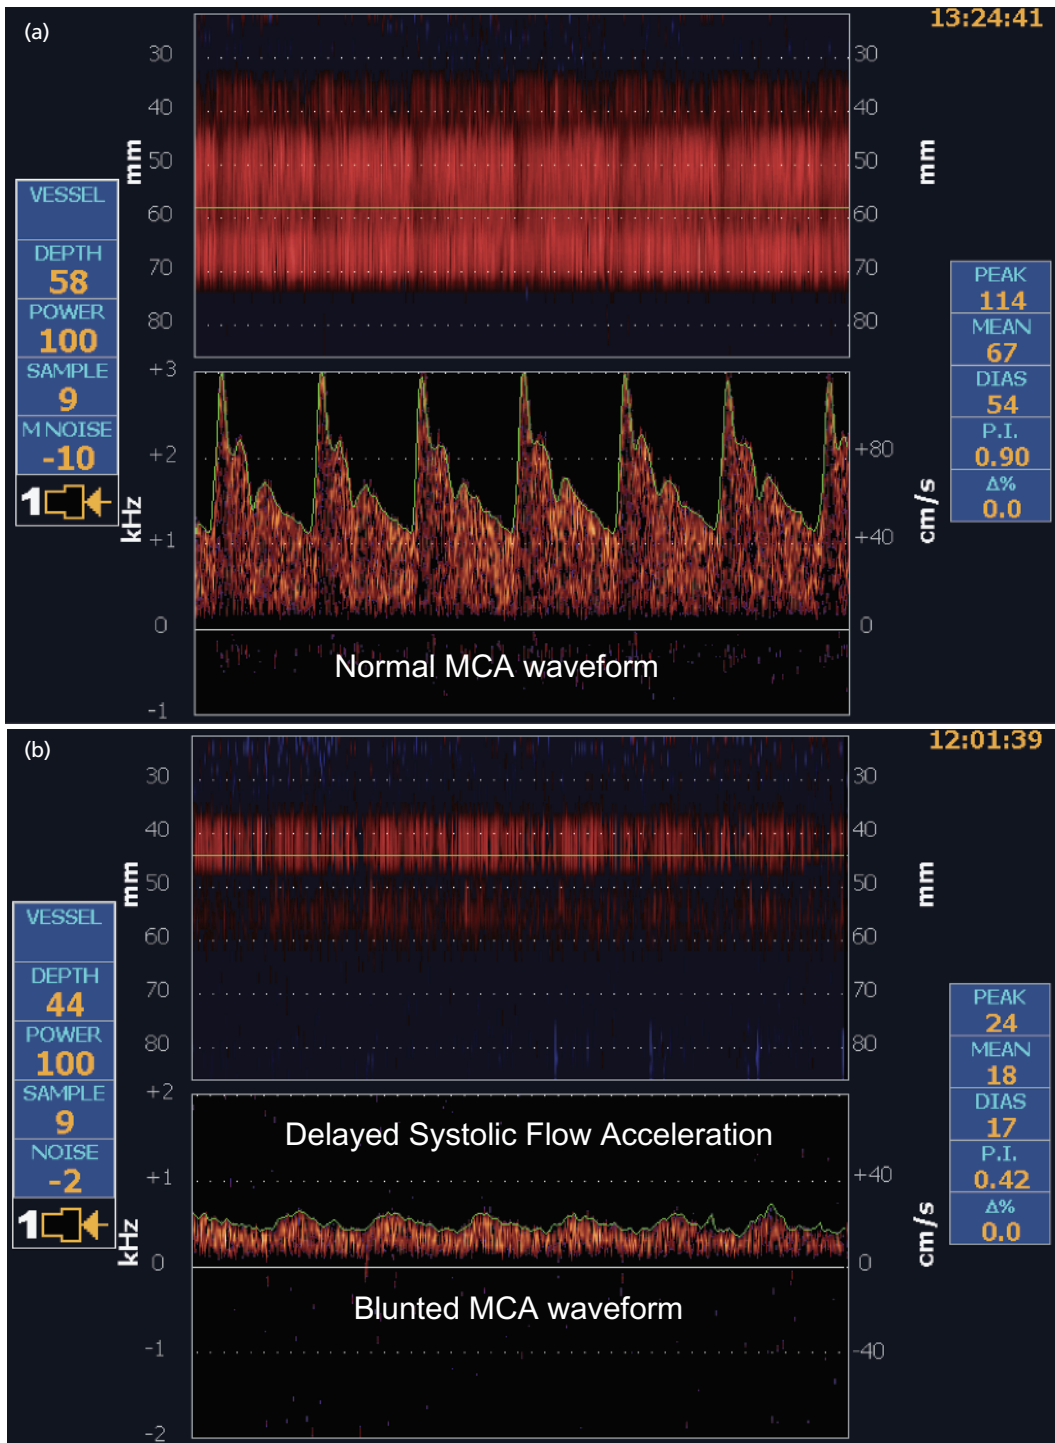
Power motion and spectral Doppler appearance of the normal and blunted MCA waveforms on transcranial Doppler. The upper part of (a) represents normal MCA appearance on motion display (vertical axis is the depth of insonation from the temporal window on the skull in mm). The lower part of (a) shows a typical spectral Doppler waveforms in the MCA with normal proximal ICA patency. (b) MCA appearance on motion display and spectral Doppler waveforms with hemodynamically significant ICA obstruction.
